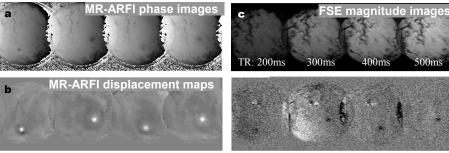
Example images for 4 out of 6 locations: a) phase images obtained with encoding gradients in the opposite direction of the ultrasound beam. b) MR-ARFI displacement maps. c) FSE magnitude images obtained during sonications. d) FSE difference images.
